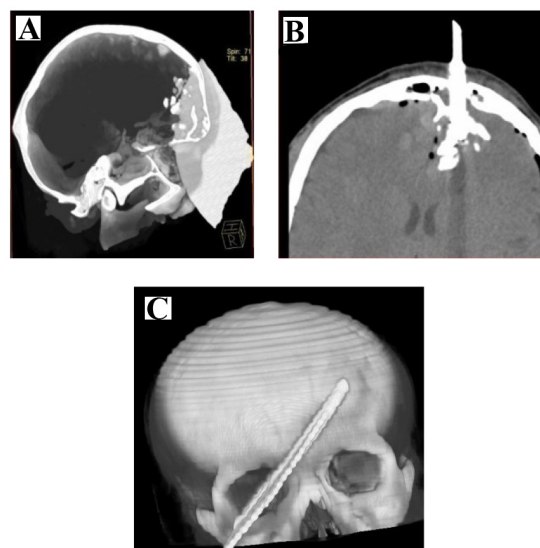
(A-C) show various head computed tomography scans of an adult, 19-year-old male with Kosarah injury. There has been injuries involving the left maxilla, orbit, frontal sinus and reaching frontal lobes of the brain.
